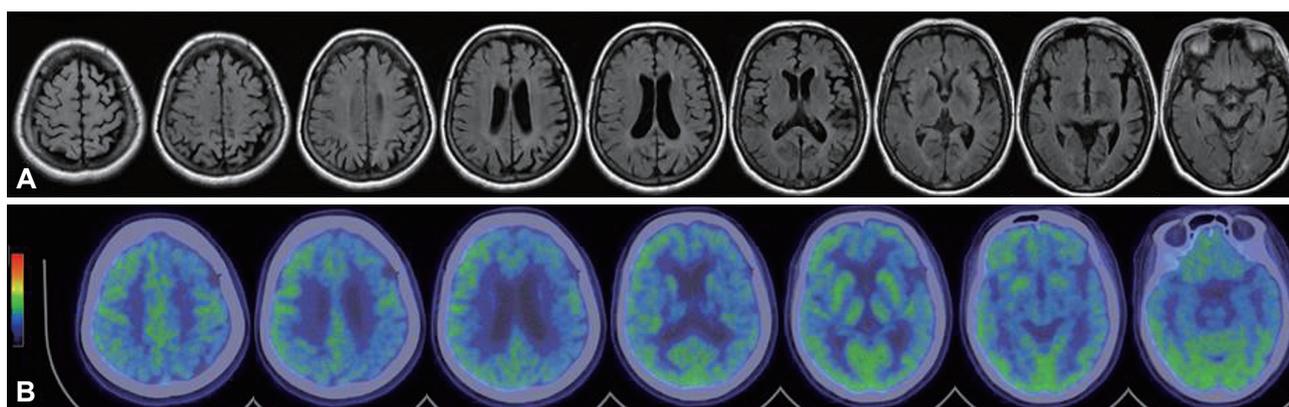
Brain MRI scan and fluorodeoxyglucose positron emission tomography (FDG-PET) scan of the patient. A: Brain MRI images showing diffuse cerebral atrophy, particularly in the left parietal cortex. B: FDG-PET images showing hypometabolism in the diffuse cortical areas, particularly in the left frontal, temporal, and parietal lobes.
